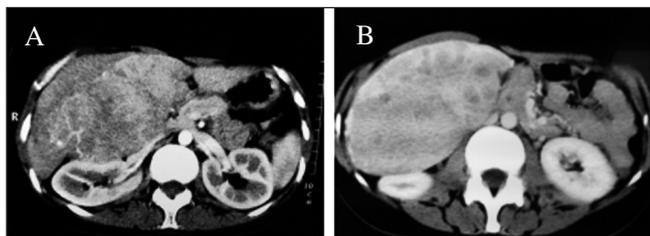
Abdominal CT scan with contrast, arterial phase (A) and venous phase (B), showing a large hypodense mass 12 cm diameter with peripheral enhancement, localized in segments 5 and 6 and displacing the right kidney and pancreas.
